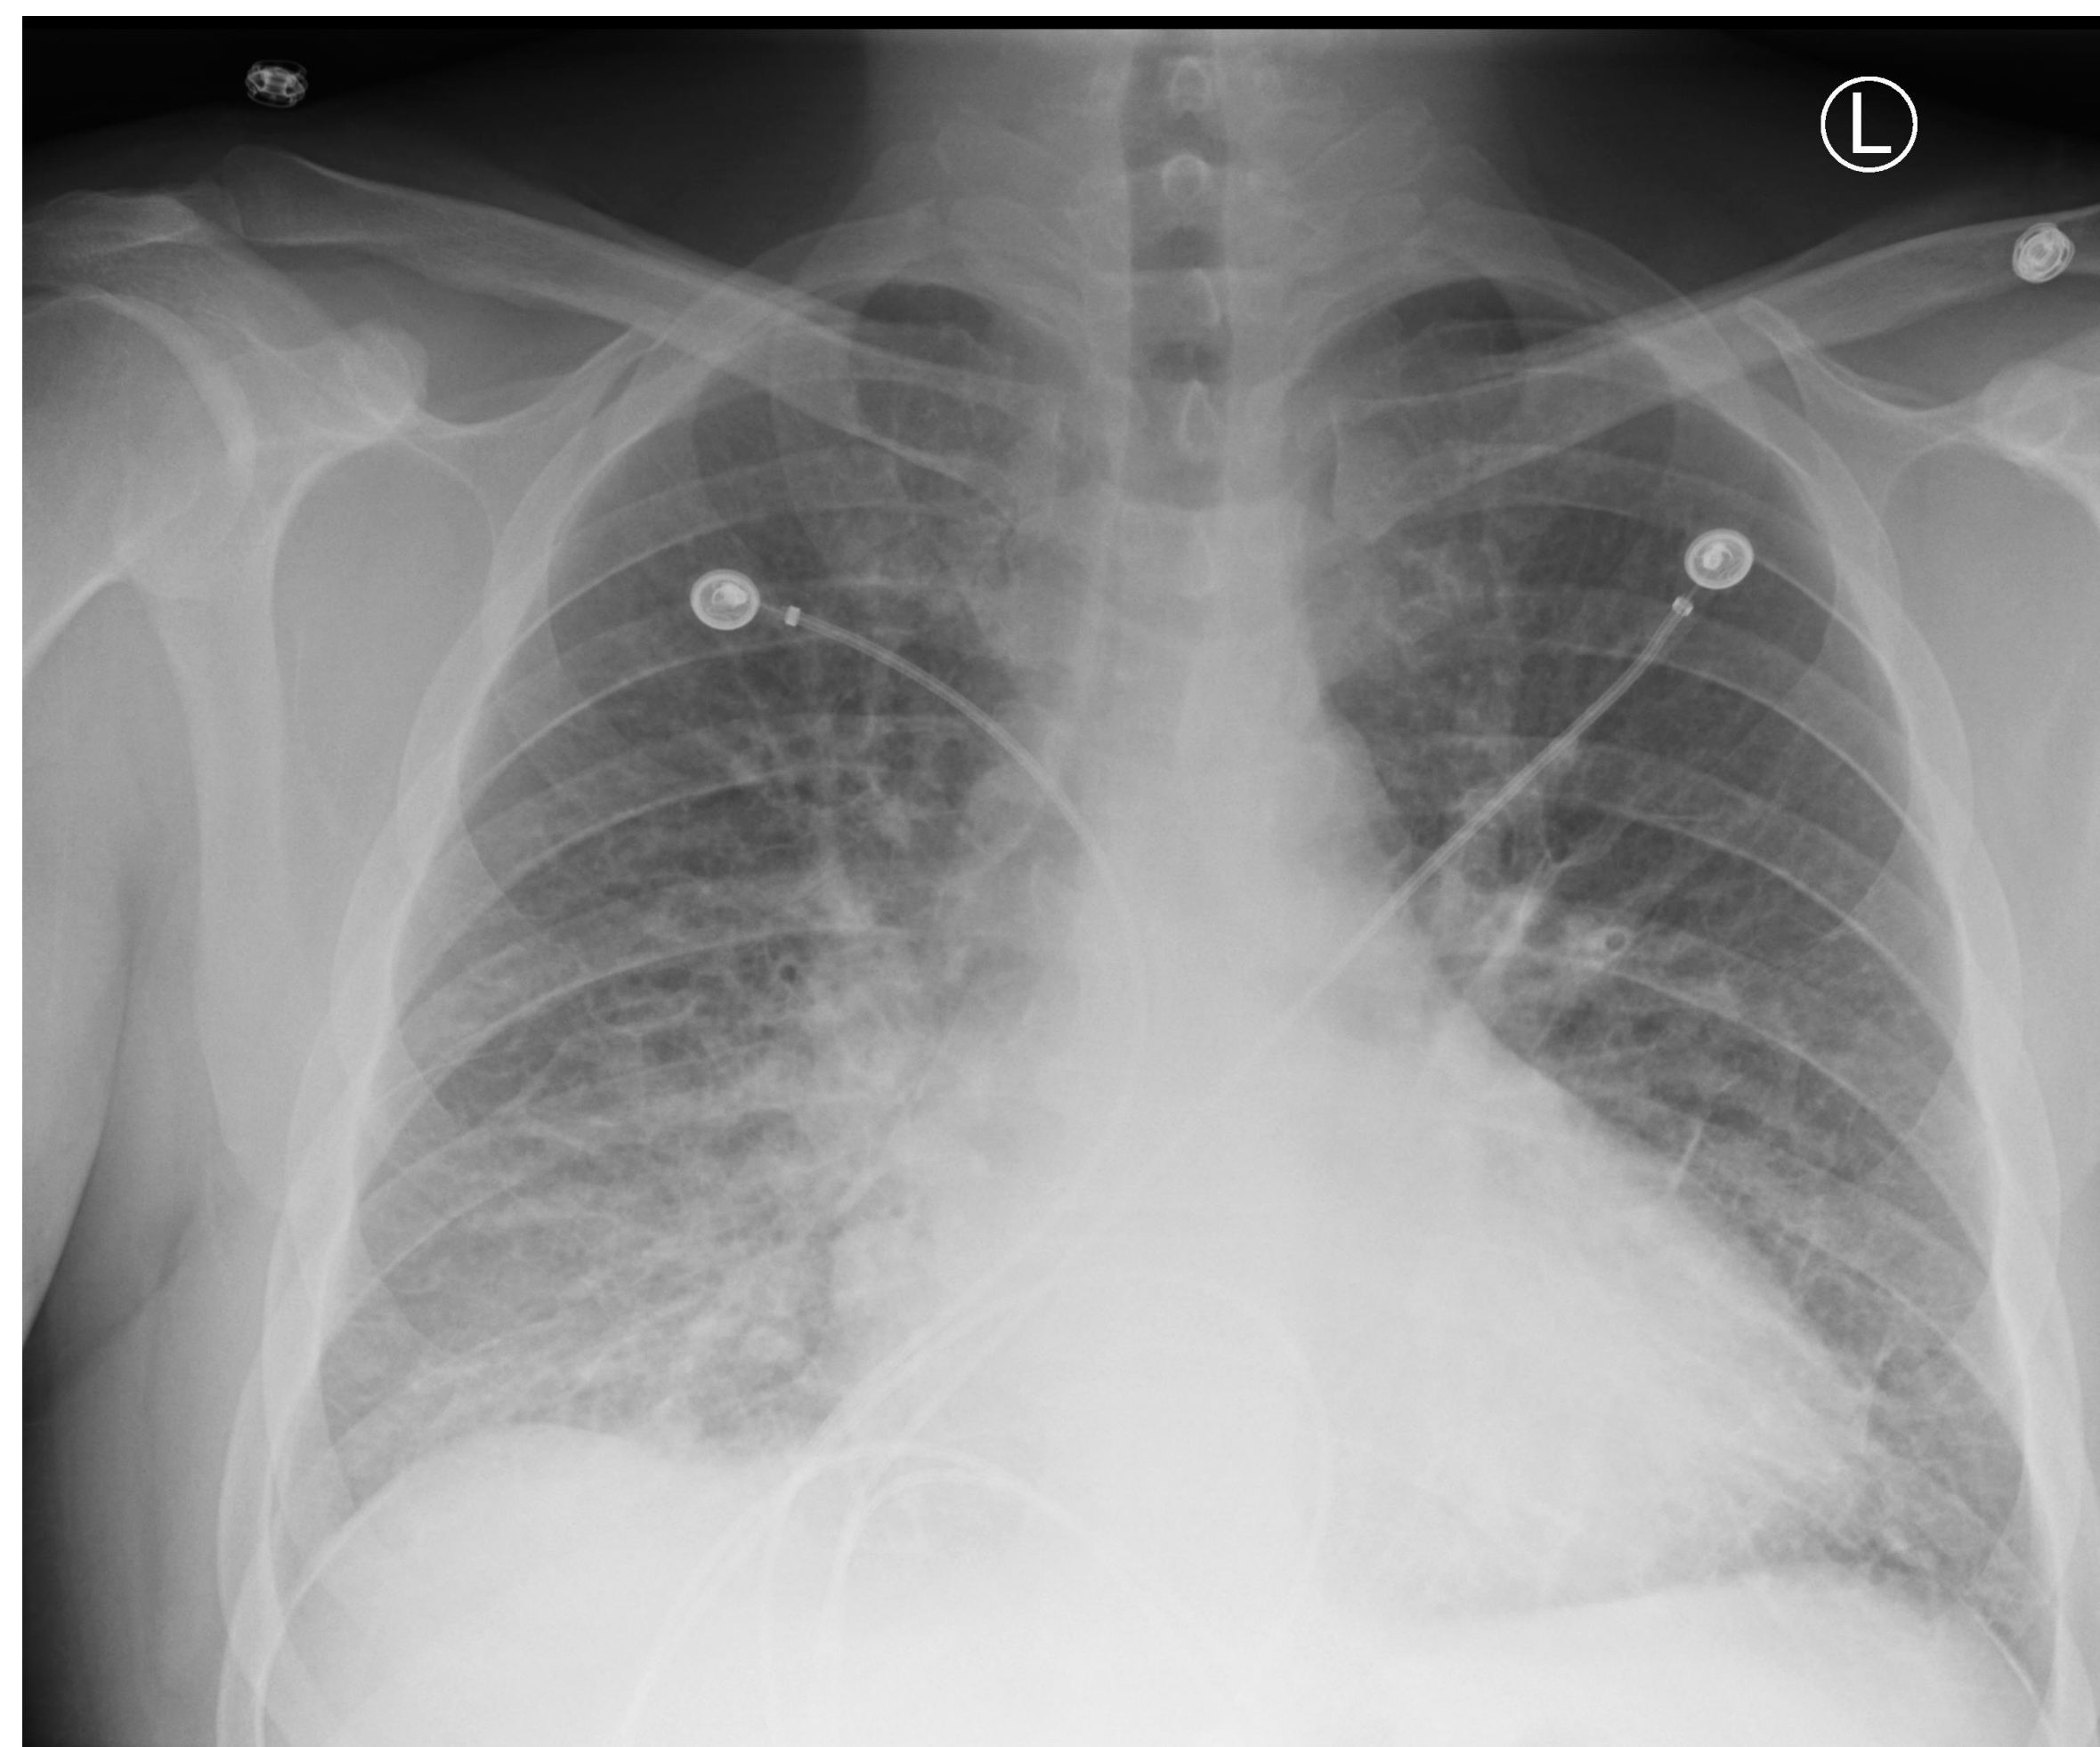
PA and Lateral Chest X-ray films demonstrating increased vascular congestion likely due to pulmonary edema in the setting of cardiogenic shock.
